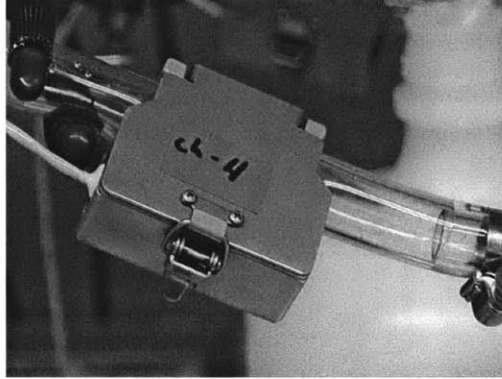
Flow sensor. Image shows Transonic ultrasonic flow sensor mounted on tubing exiting model.
